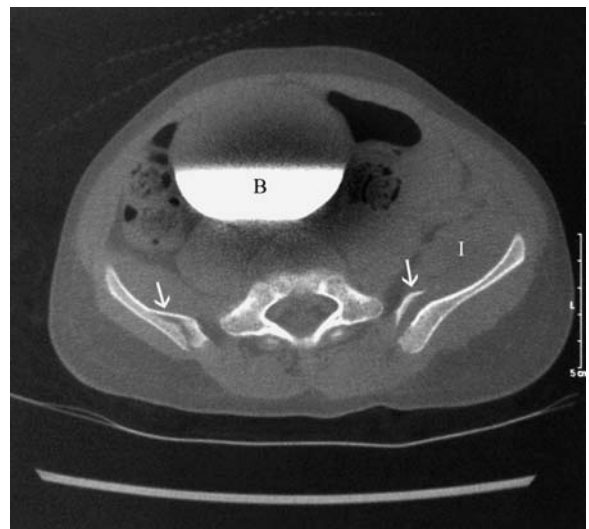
Fractures on CT
